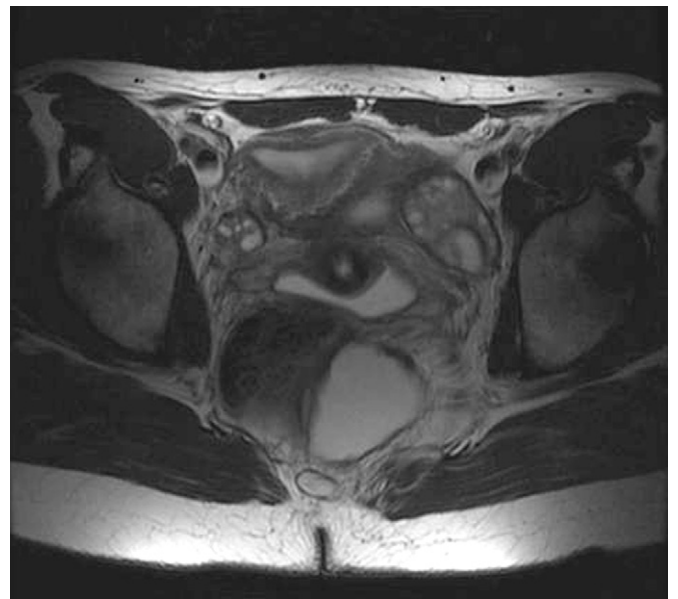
Magnetic resonance image in a 17-year-old girl with a rectal duplication that became infected. It was initially treated with percutaneous external drainage followed by subsequent resection using a posterior sagittal approach.
